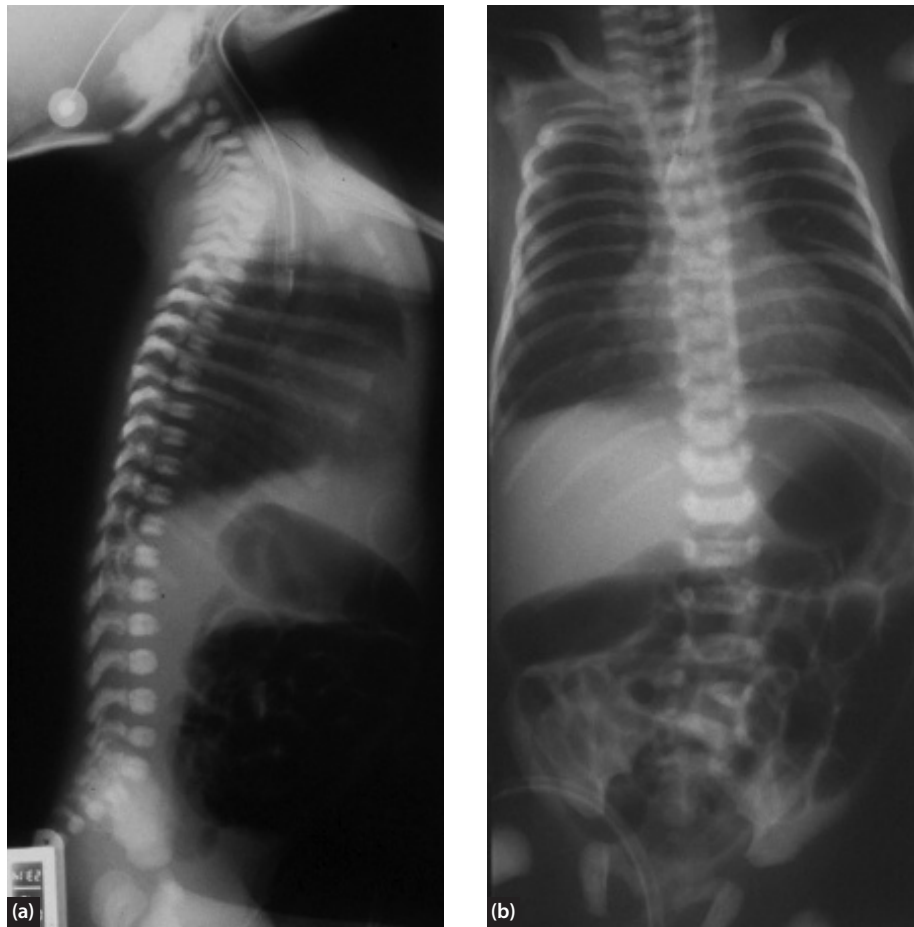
Lateral (a) and AP (b) chest and abdominal X-rays of a newborn with OA and TOF. A large-bore tube has been placed under tension in the upper pouch. The stomach and intestine contain air which indicates the presence of a TOF. Vertebral anomalies can be seen in the mid thoracic spine.
